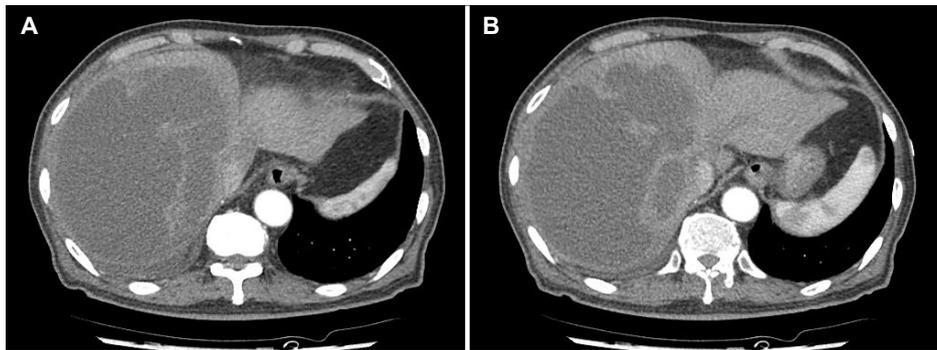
Computed tomography (CT) scan of the abdomen. (A, B) Initial abdominal CT shows massive, multiple abscesses in the right lobe of the liver.
